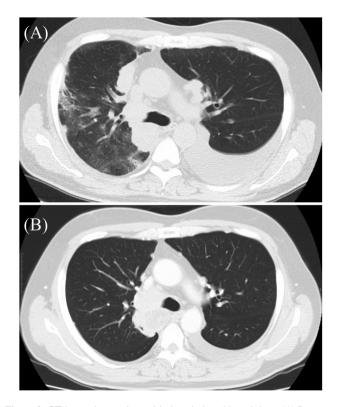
CT image in a patient with drug-induced lung injury. (A) Image at the onset of Pneumonitis. Pneumonitis with DAD pattern in a 58-year-old man demonstrated diffuse ground-glass and consolidation after receiving 8 doses of nivolumab and then 13 doses of cetuximab. Steroid treatment brought him lull, but further anticancer drug treatment could not be continued. (B) Image taken 4 months before the onset of pneumonitis showed no evidence of pneumonia. CT, compute tomography; DAD, diffuse alveolar damage.
